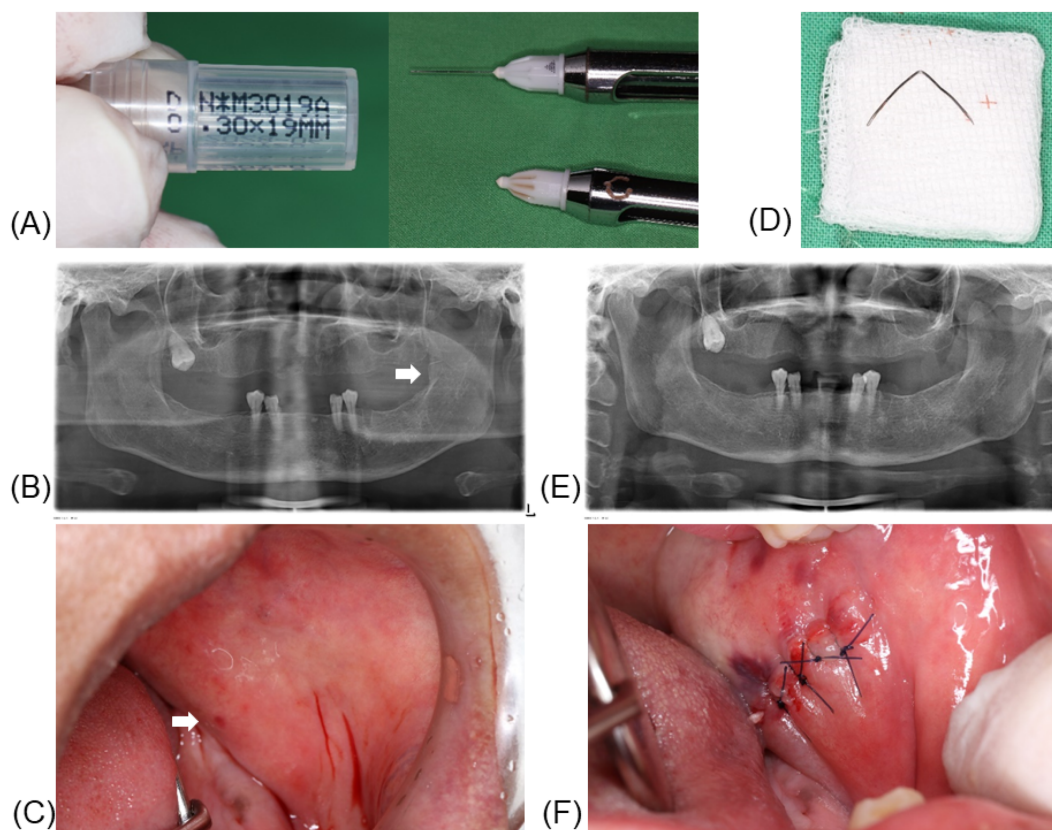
Conventional surgical exploration for needle retrieval. A local dentist referred a patient to the Emergency Dental Department, Kaohsiung Veterans General Hospital, following an accidental needle breakage during inferior alveolar nerve block (IANB). (A) The faulty needle and a counterpart of identical dimensions (30-gauge, 19 mm) were presented at the hospital. The broken needle was completely detached from the hub. (B) An orthopantomogram was performed for initial evaluation, and revealed a deformed needle (white arrow) at the anterior border of left mandibular ramus. The patient was asymptomatic and denied any problems with mouth opening. (C) A red spot was observed in the left pterygomandibular raphe area. Using this red spot (white arrow) as an initial reference, a mucosal incision was performed, and followed by blunt dissection under tissue tension formed by assistant's finger. (D) The needle was successfully retrieved after exploration and careful dissection. (E) Another orthopantomogram confirmed the complete removal of the needle. (F) The soft tissue was sutured with 4-0 nylon. In the present case, neither the patient nor the referring dentist reported any sudden or forceful movements during anesthesia procedures. The use of short needle for IANB was a major risk factor for its breakage. The deformation of the needle implied that needle was bent prior to the injection, or that it had an aggressive contact with the bone during administration. In addition, IANB usually was not needed for a mandibular first premolar extraction; instead, local infiltration might be sufficient.
